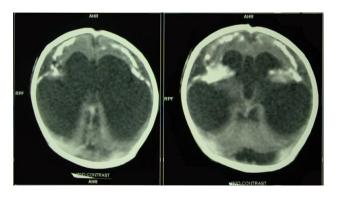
CT scan brain at the age of 7 days showed hydrocephalus and diffuse cortical calcifications.
